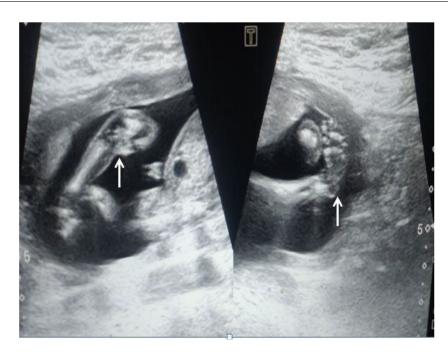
Oblique B-mode ultrasound image of bilateral lower limb showing both tibia and fibula in same image plane as of medially deviated foot—suggestive of bilateral club foots (marked by white arrows).
